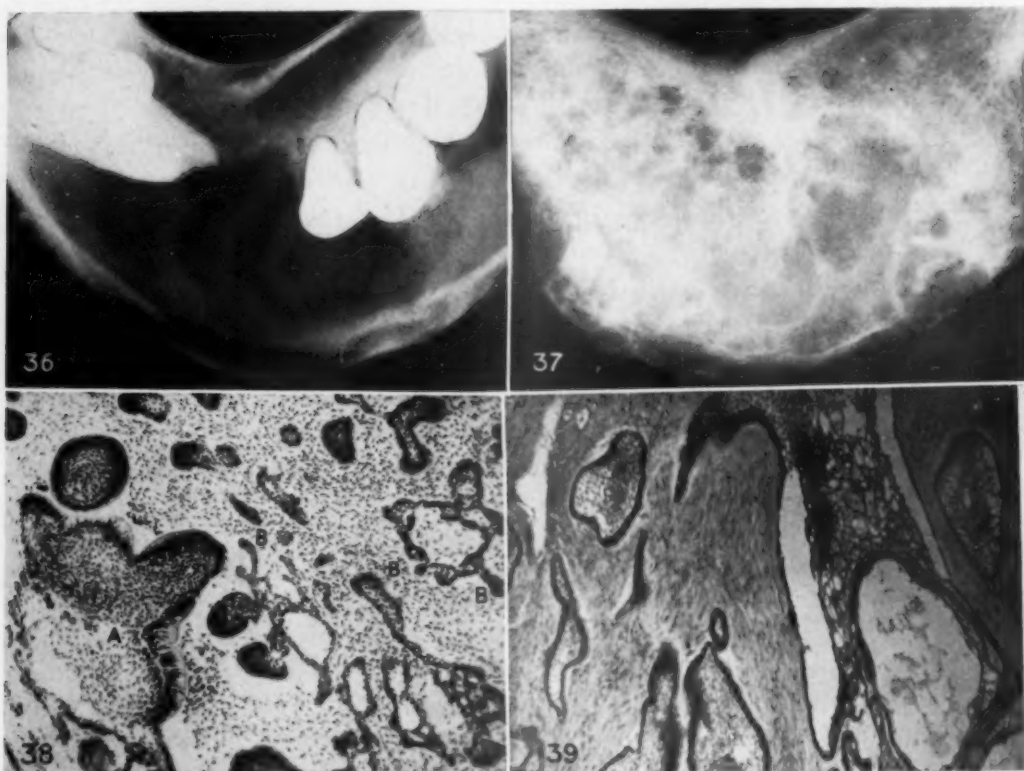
Case 11. Radiograph of chronologically young solid ameloblastoma.
